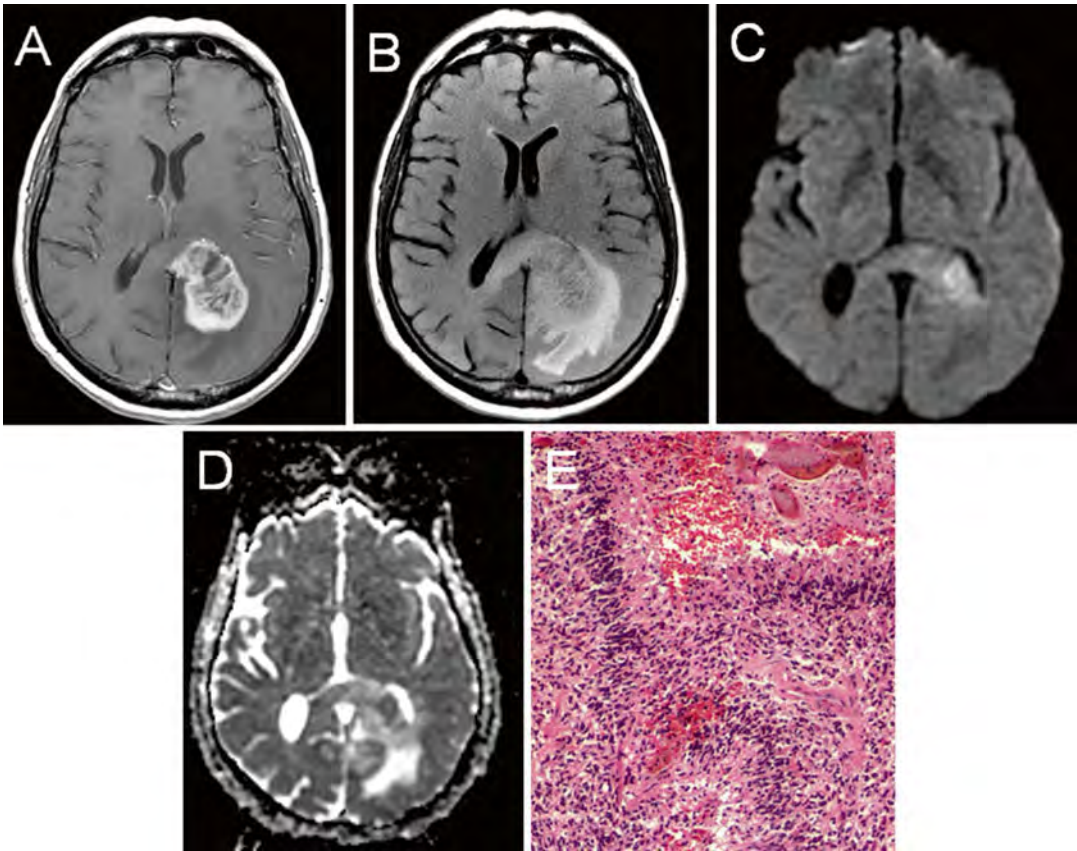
T1 axial post-gadolinium (a), T2 FLAIR (b), diffusion-weighted imaging (c), and apparent diffusion coefficient (d) imaging of a left-hemisphere glioblastoma. The peripheral enhancing pattern and nonenhancing expansile changes crossing the midline via the corpus callosum are
